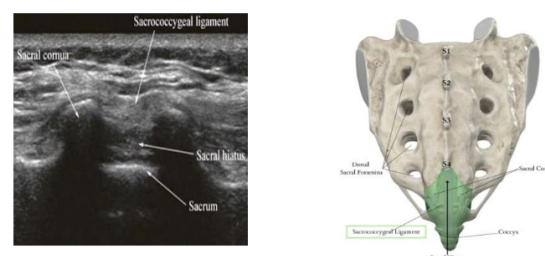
Ultrasound anatomical landmarks (image from "Ny-sora, Ultrasound-guided central neuraxial blocks")
